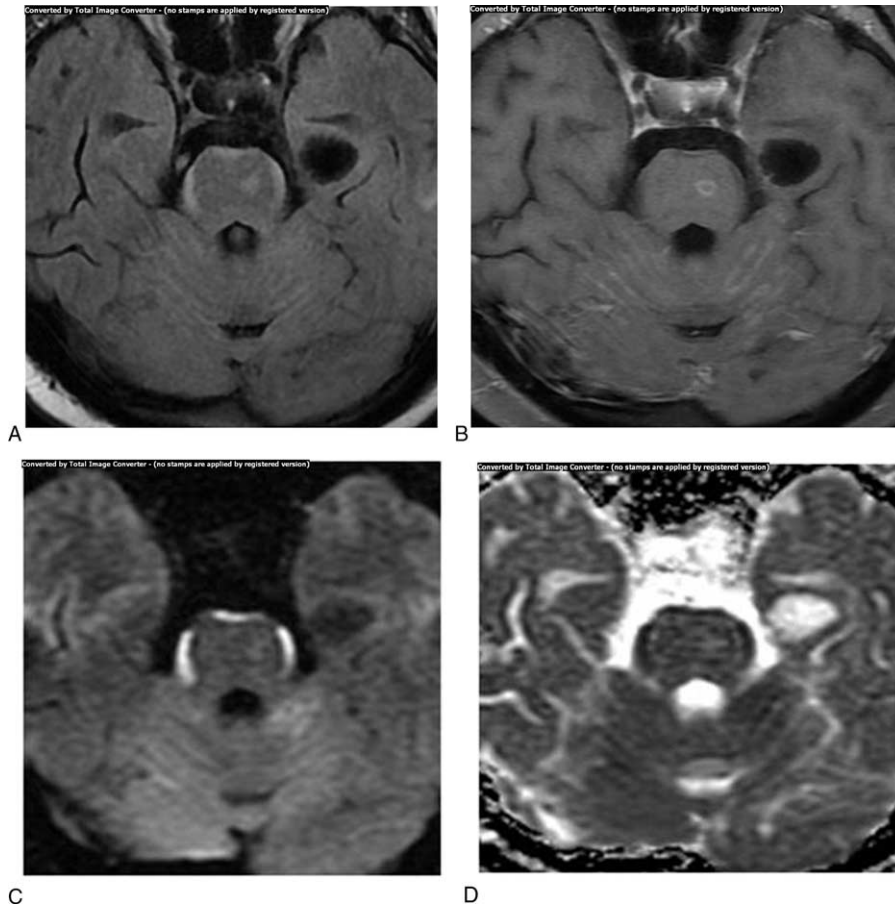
Case 2. A 47-year-old woman with lung adenocarcinoma. (A) A T2-FLAIR image reveals bilateral symmetrical curvilinear high signal intensity on the surface of the anterior pons. (B) A contrast-enhanced T1-weighted image shows no enhancement. There are diffuse linear enhancing lesions along the cerebellar folia, consistent with leptomeningeal metastasis. (C) DWI. (D) An ADC map demonstrates symmetrical band-like cytotoxic edema along the surface of the pons.
